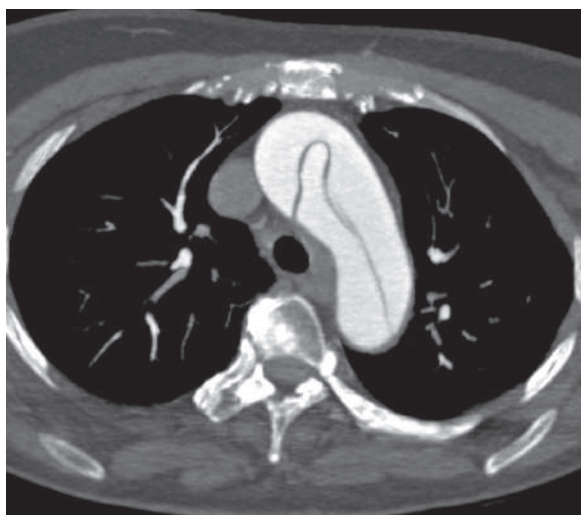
Axial CT-angiography shows the classical intimal flap in a patient with aortic dissection Stanford type A
